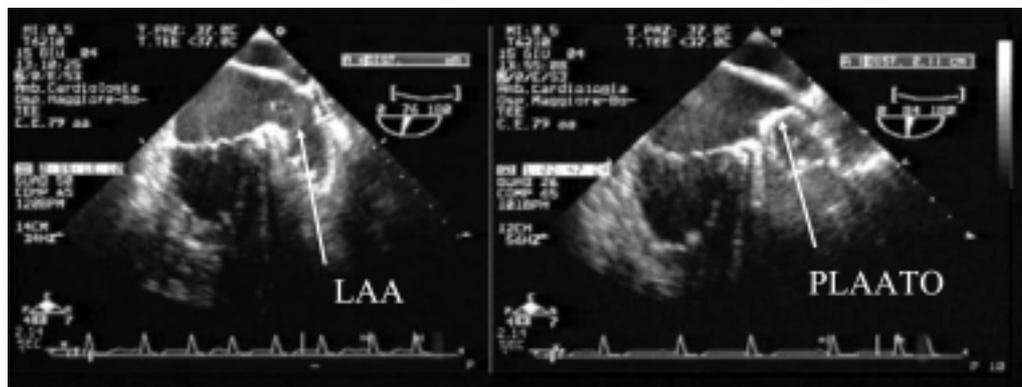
Transesophageal echocardiographic images, view at about 90°, showing the left atrial appendage (LAA) before, free of every thrombus, and after PLAATO implantation. The appropriate sealing of the LAA is visible.
